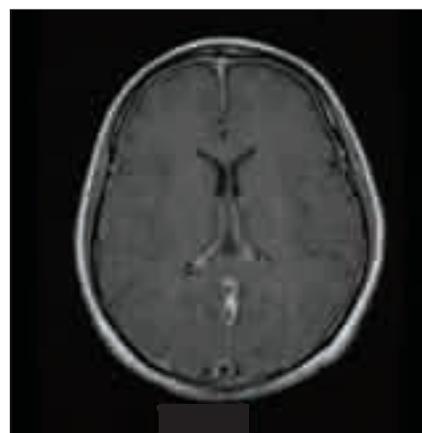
Enhanced magnetic resonance imaging demonstrating diffuse non-nodular, uninterrupted pachymeningeal gadolinium enhancement.
